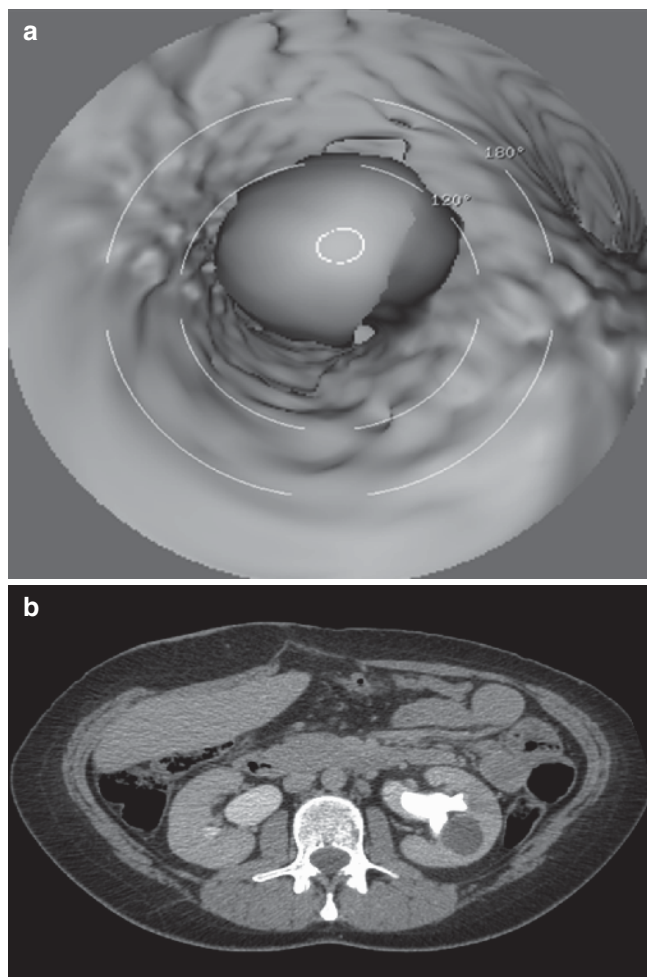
Virtual endoscopic view of a staghorn calculus (a). The corresponding axial image of the calculus is seen on the CT urogram (b)
